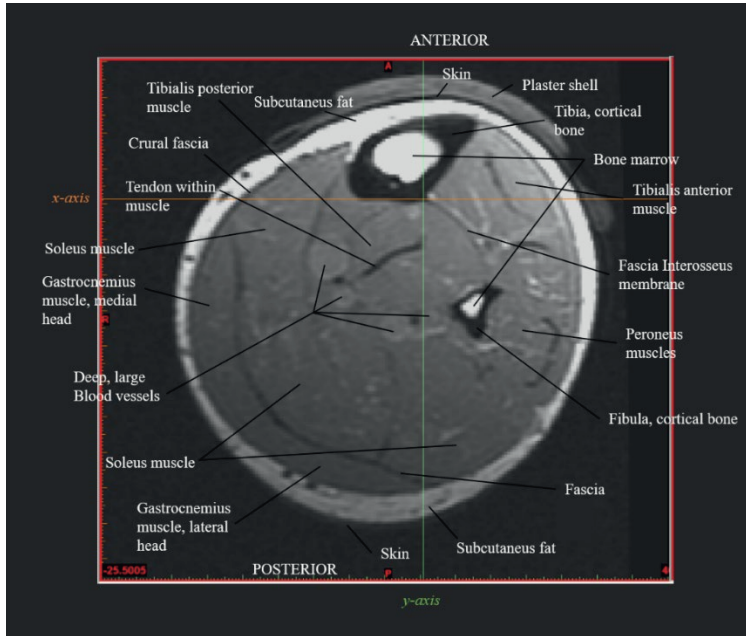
Examples of identified tissues in MR image of no-loaded condition at the level of indentation. MR image had y-axis positive direction downwards, towards posterior side.
